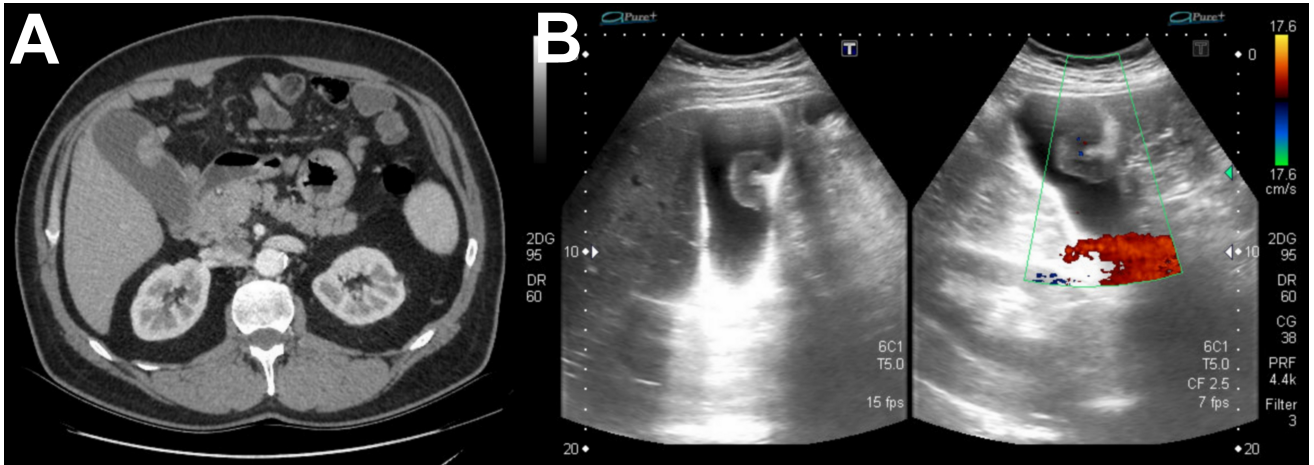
Radiological proofs. A. Abdominal computed tomography in which an image of higher density is shown in the gallbladder. B. Abdominal sonography in which a 27 mm vegetative image is shown that is part of the wall of the gallbladder, with doppler flow inside.
